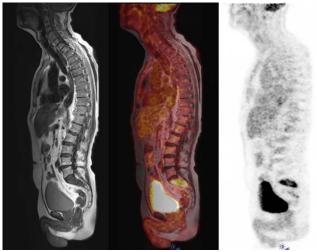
PET/MRI of a patient with esophageal cancer and metastasis to the sacral bone
